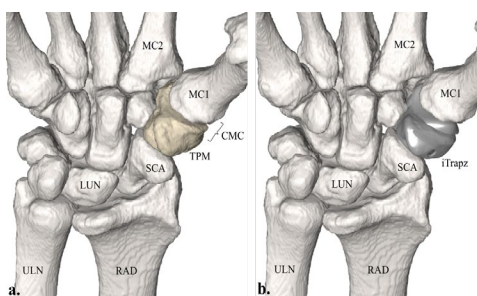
Palmar view of the skeletal hand (a) segmented from a CT volume. The trapezium carpal bone (TPM) will be replaced with the load sensing iTrapz (b) in patients undergoing trapeziectomy for severe osteoarthritis.
